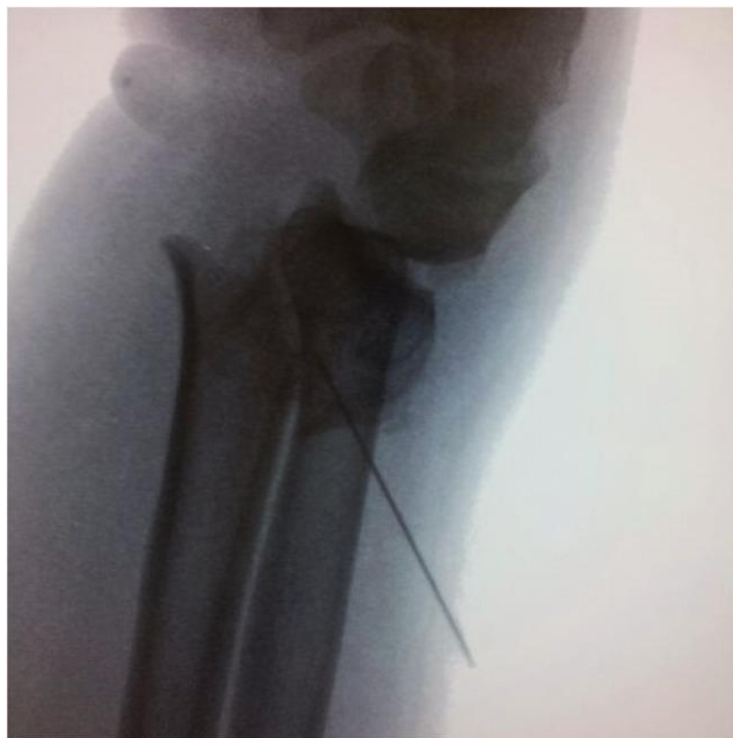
HB's X-ray indicates a fracture of the distal radius
